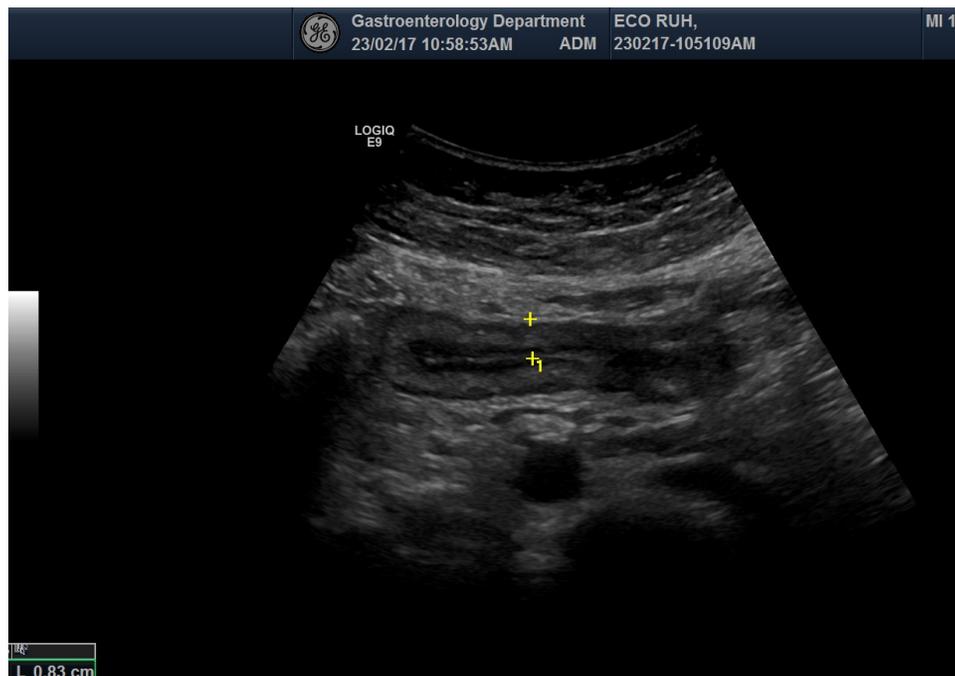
Ulcerative colitis. Transabdominal ultrasound – descending colon with thickened wall.
